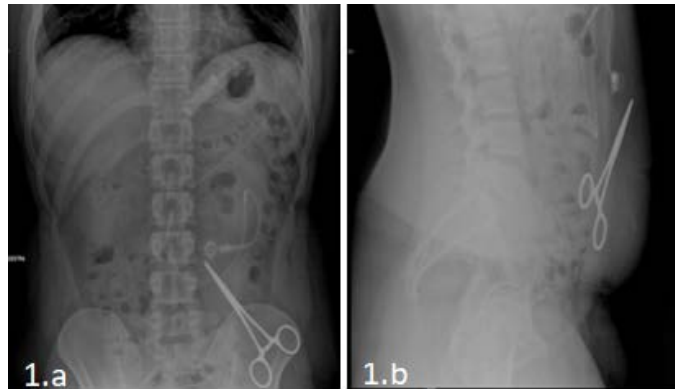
Plain X-ray of the abdomen in orthostatic PA (1.a) and LL (1.b) view demonstrates a metallic foreign body in left flank/left iliac fossa.
